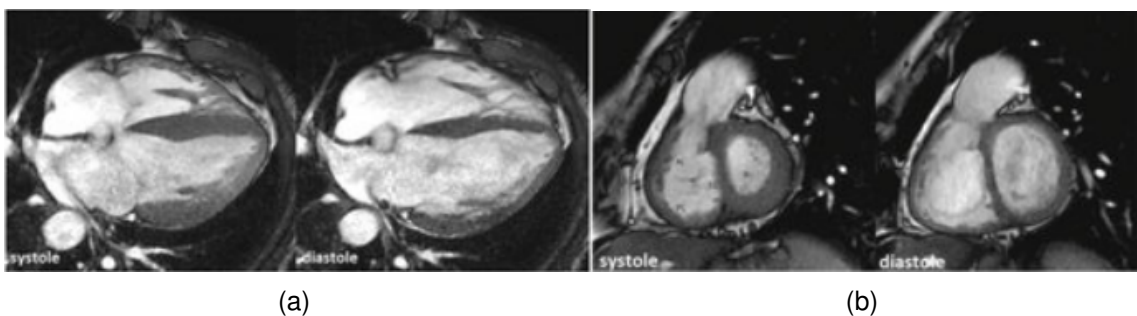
CMRI. a) Cine MRI HLA. b) Cine MRI SA [73].
